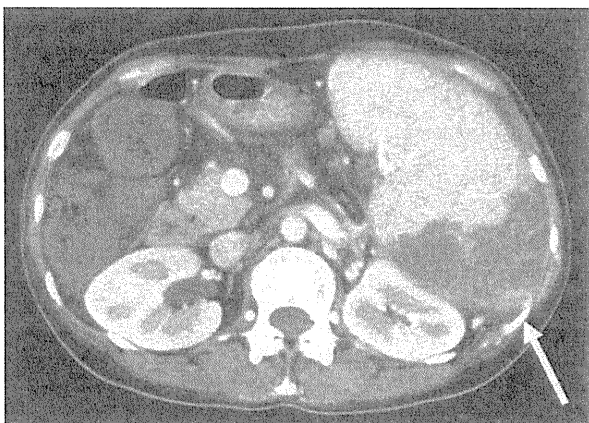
Abdominal CT with contrast medium demonstrating partial splenic infarct demonstrated by a lack of contrast enhancement of the lower pole of the spleen (white arrow head)
